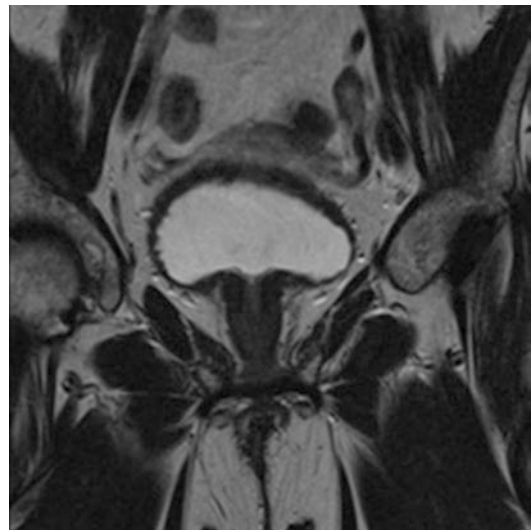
MRI female stricture. (Courtesy of Tamsin Greenwell, MD)
